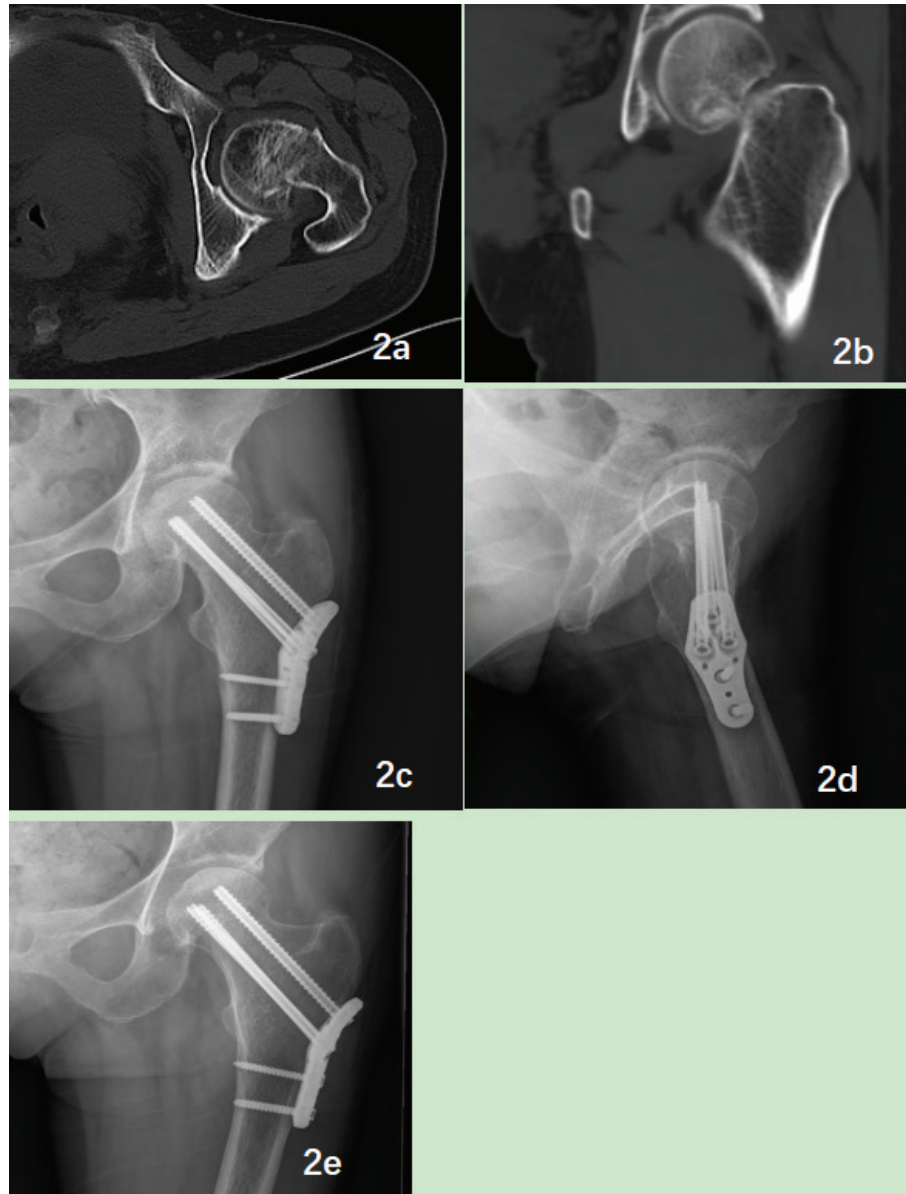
(a and b): Preoperative hip CT scan of a 54 year-old female patient with displaced intracapsular hip fracture. (c and d): The 3 months postoperative X-ray showed fracture healed without orthopedic complications. (e): The 2 years postoperative X-ray of the fractured site was bone union without implement failure or femoral neck shortening.
